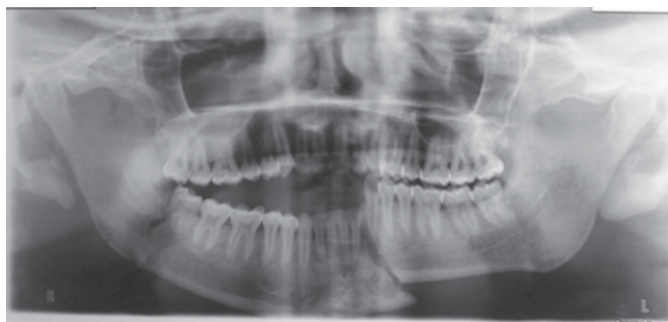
X-ray film showing fracture at left parasymphysis and right angle of mandible
